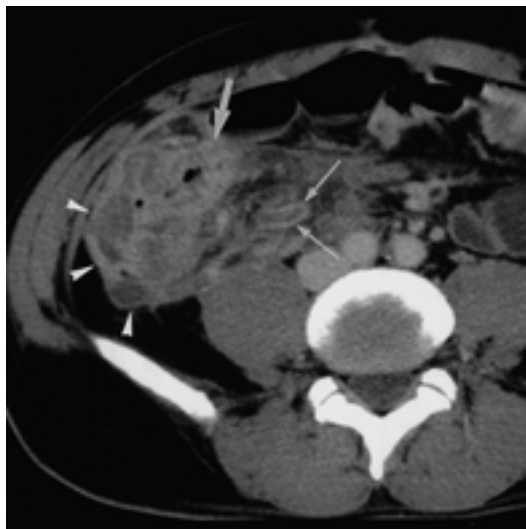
Typhlitis related with severe neutropenia in a 35-year-old man. Contrast-enhanced CT scan shows segmental wall thickening involving the cecum (arrowheads) and terminal ileum (thick arrow). Mild enhancing appendix (thin arrows) and moderate inflammatory changes of adjacent mesenteric fat are seen.
